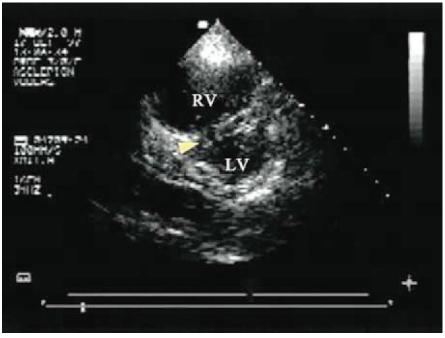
Parasternal short-axis view of the right and left ventricles in a patient with PE showing diastolic flattening of the intraventricular septum as a result of pressure overload. LV, left ventricle; RV, right ventricle.
